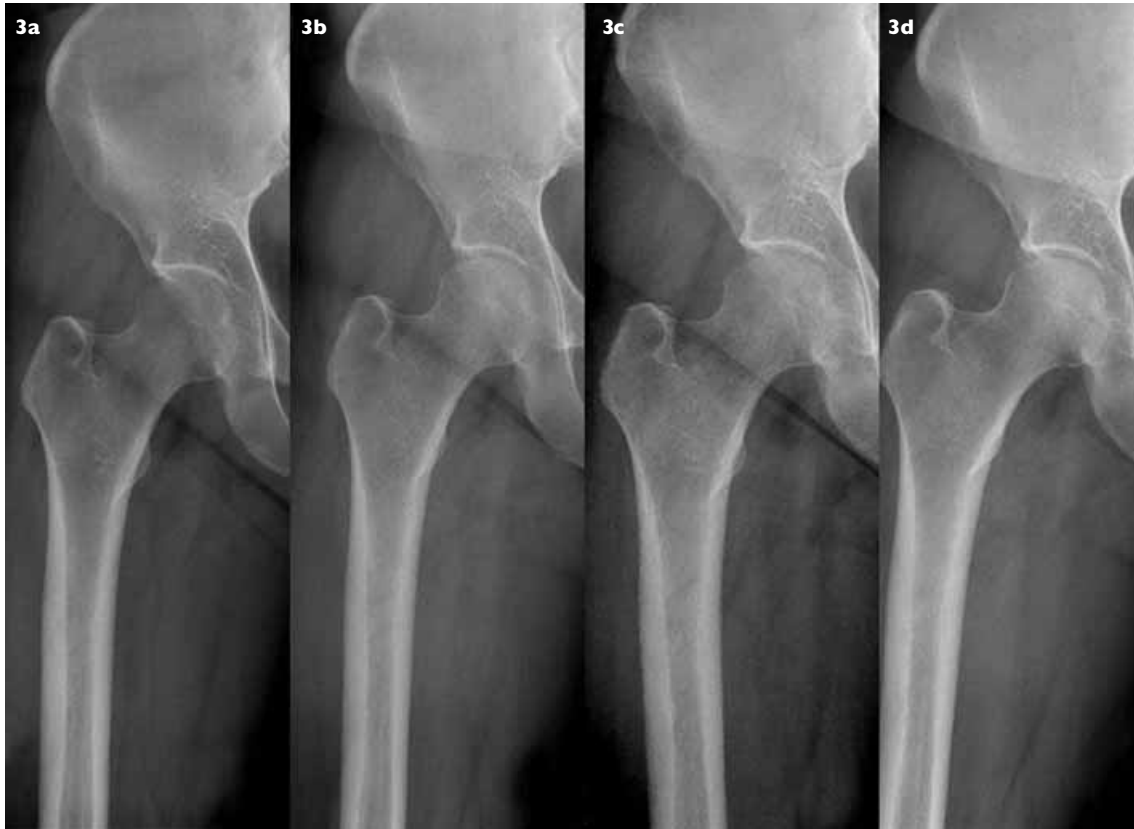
Case 2. Serial anteroposterior radiographs of the right proximal femur. (a) Radiograph taken at the time of diagnosis shows diffuse osteopenia affecting the right femoral head and neck regions. Radiographs taken at (b) one month and (c) four months, show an improved trabecular pattern. (d) Radiograph taken after 7 months shows a normal femoral head and neck density.
